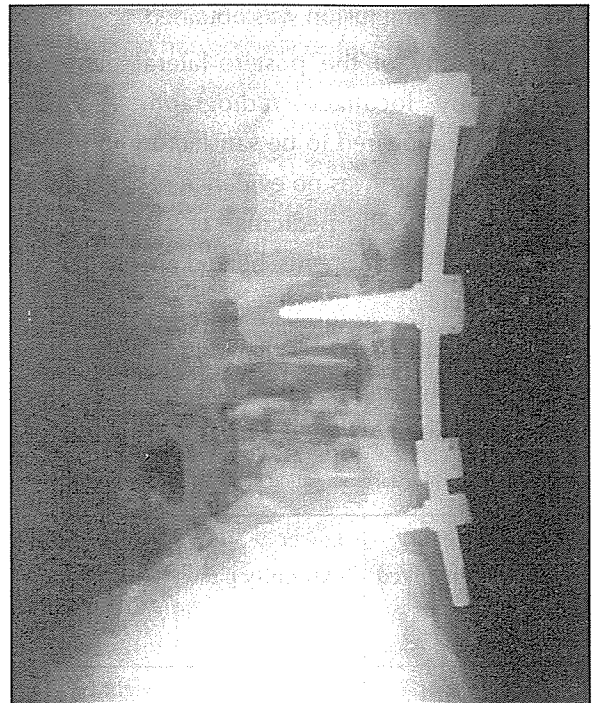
Postoperative lateral roentgenograms of the same patient after total bilateral laminectomy, posterolateral fusion and posterior instrumentation.
